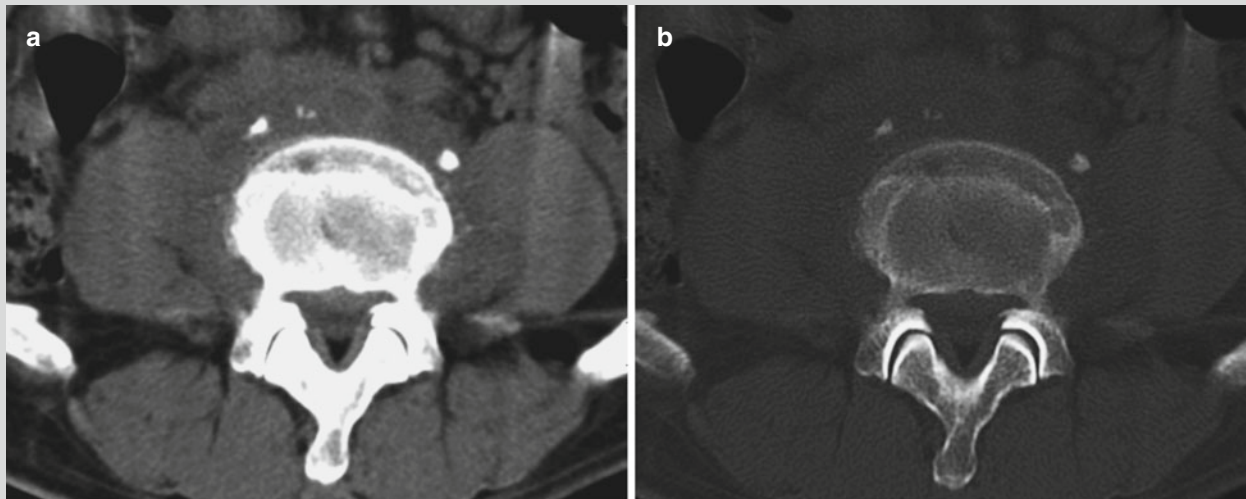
Brucellar spondylitis. (a, b) Plain lumbar CT scanning demonstrates vertebral osteoproliferation, low uneven density shadow surrounding the vertebra with poorly defined boundaries.
